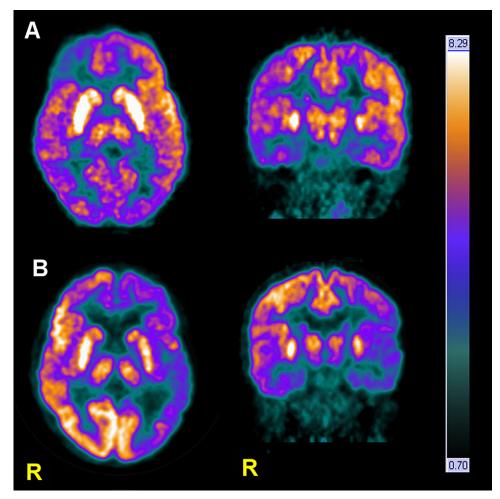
[18F]Fluorodeoxyglucose PET-CT images from case 1 (A) and case 2 (B): transaxial and coronal views in warm metal display. White to orange color represents normal metabolism. R indicates right side. (A) Case 1 exhibited generalized marked reduction in cortical metabolism in both hemispheres, the right more than the left, involving bilateral frontal, temporal, parietal, and occipital regions. Both thalami have symmetric mildly reduced metabolic activity. The basal ganglia exhibited normal symmetric activity. (B) Case 2 exhibited a marked reduction in cerebral metabolism in the entire left hemisphere, both temporal lobes, and the right frontal lobe. The thalami exhibited a mild reduction in metabolism. The basal ganglia exhibited normal symmetric activity.
